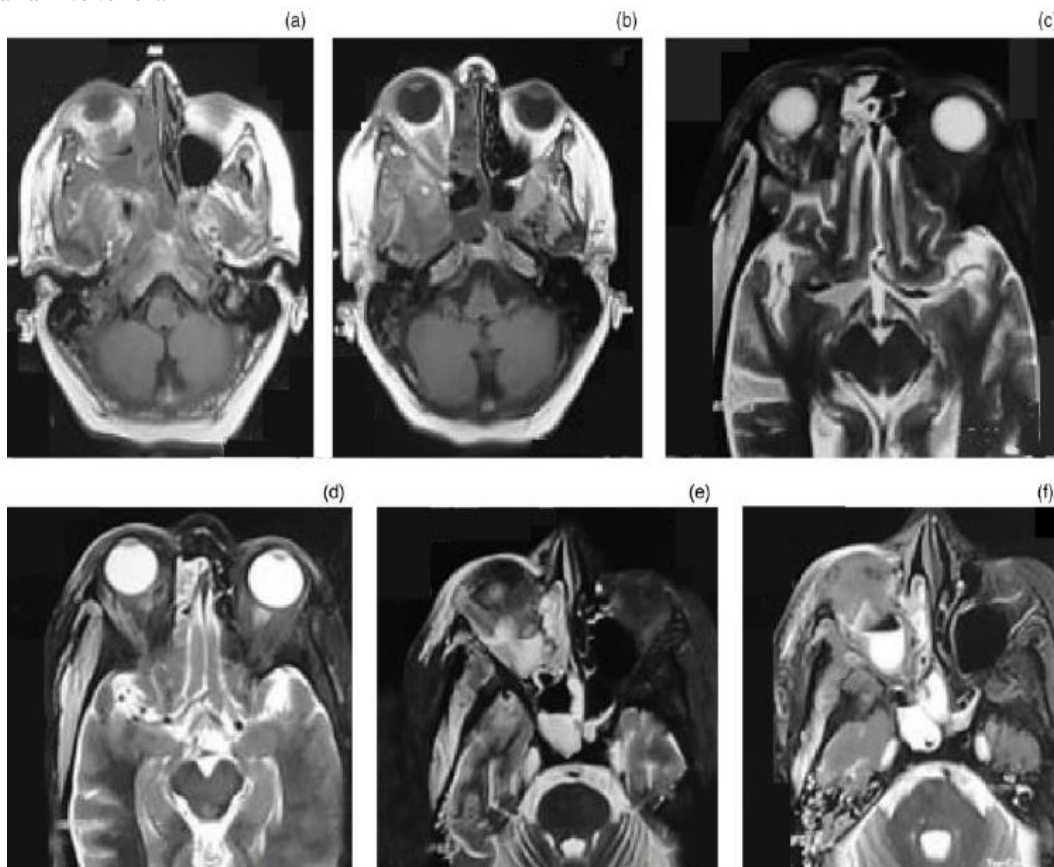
(a–f) Axial, magnetic resonance imaging scans showing intra-orbital extension of mucormycosis.
